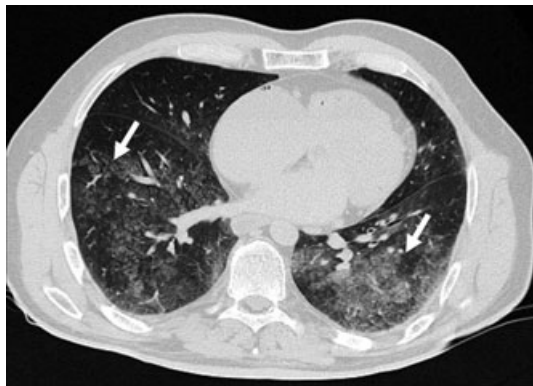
Pulmonary CT findings in a case (n. 21) with anterograde aspiration. A transverse multidetector CT image shows rounded areas of ground-glass opacity in both lungs and within the entire cross-sectional area (arrows).
